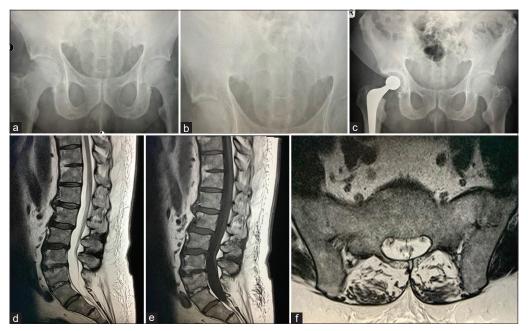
Patient presented with persistent right hip pain to the hip surgeon. An initial plain radiograph (a) was performed for the right hip pain which showed no significant degenerative change. The patient represented to orthopedics 1 year later with persistent pain and a subsequent pelvic radiograph (b) again demonstrated no degenerative change in the right hip. A right hip replacement was subsequently performed, though indications were not clear (c). Note that on all three radiographs, (a-c) bilateral sacroiliac joint (SIJ) sclerosis is present but was not reported, and therefore, patient was not referred for a rheumatological opinion. (d,e) The patient's hip pain continued post-hip replacement and (f) subsequent referral to spine surgeons was made for sciatica. Imaging of the spine with the last magnetic resonance imaging slice through the SIJs demonstrates ankylosis of the SIJ, corner fat lesions, and syndesmophtyes in the spine.
